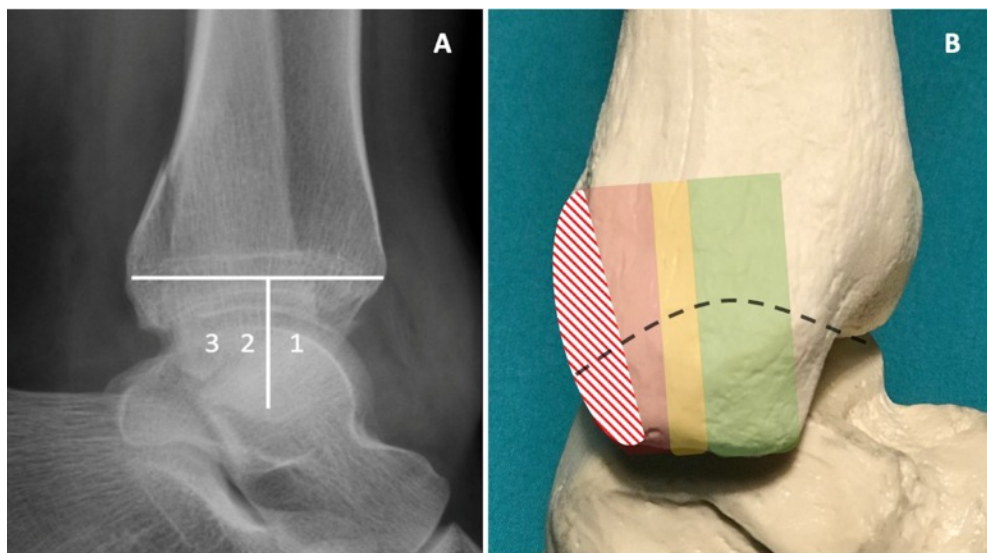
Lateral ankle radiograph (A) and sawbone model (B) demonstrating the safe zone (zone 1 - green) of the medial malleolus.
